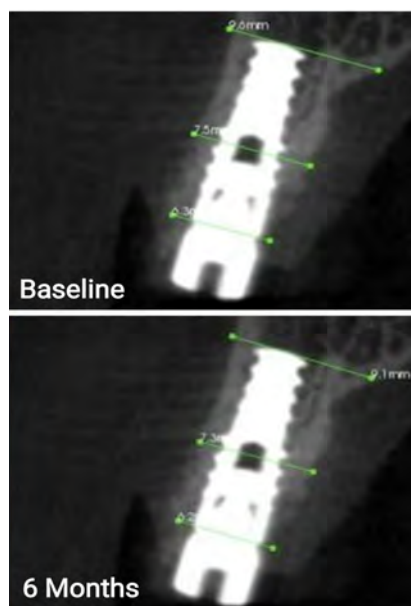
Bucco-palatal CBCT measurements recorded at Baseline (Day 0) and 6 Months
